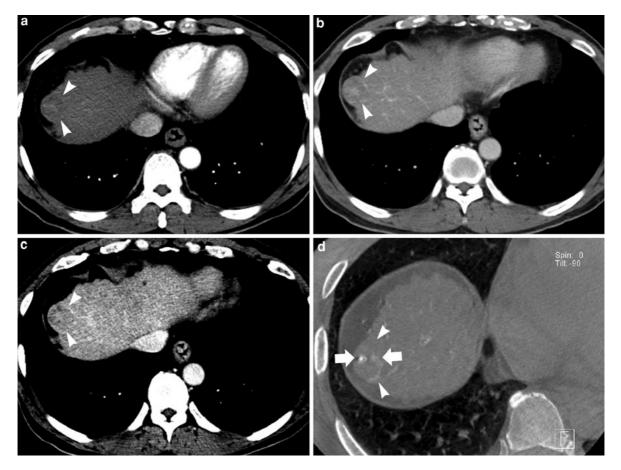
Small HCC in dysplastic nodule showing "nodule in nodule" appearance. a Arterial phase CT scan shows a small enhancing focus with a hypoattenuated nodule in segment 8 (*arrowheads*). b and c Portal phase (b) and delayed phase (c) CT scans show a central enhancing focus within a hypoattenuated nodule. d Dyna-CT scan shows two enhancing foci (*arrows*)
